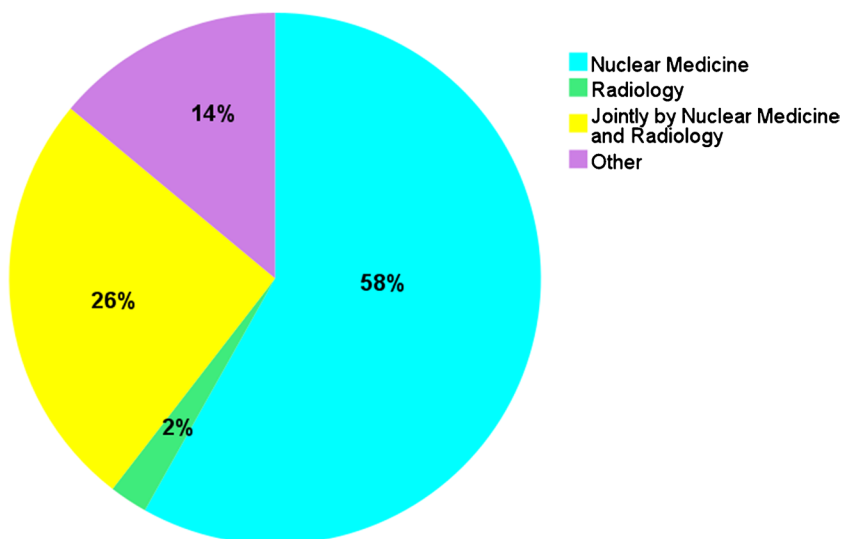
Percentage of employees working on PET/MRI
